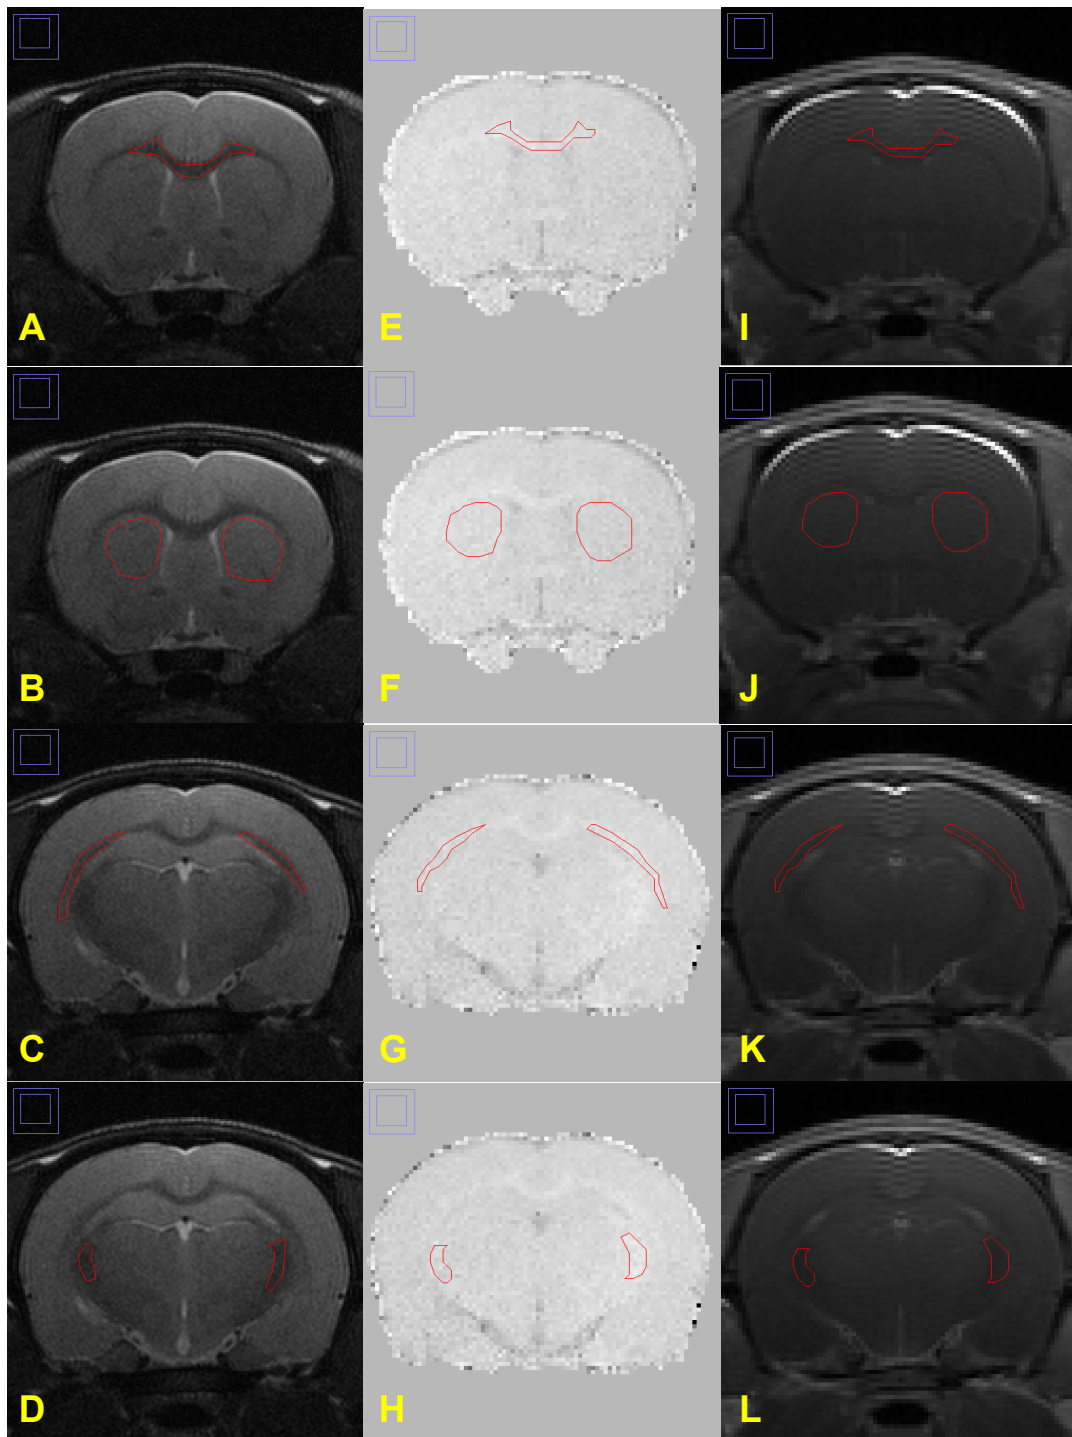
Coronal MRI images to show the ROIs selected within the corpus callosum (A, E, I), the caudatoputamen (B, F, J), the external capsule (C, G, K) and the internal capsule (D, H, L), delineated by red boundaries, in the T2-weighted images (A-D), MTR parametric maps (E-H) and T1-weighted images after the injection of Gd-DOTA (I-L).
